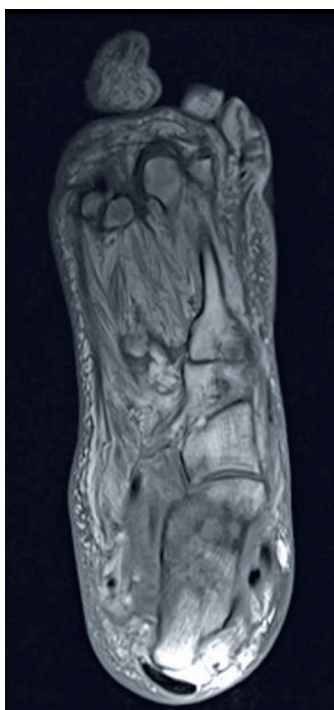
Axial view magnetic resonance imaging scan. Comparative T1 and T2 images, as well as the presence of apparent abscesses in the calcaneus.
